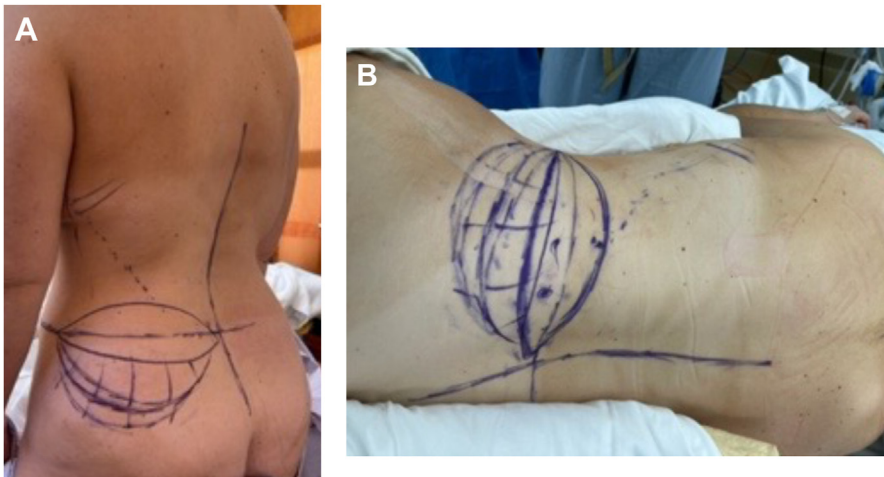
LAP flap markings shown preoperatively (A) and on the operating room table with the patient positioned in lateral decubitus (B). The skin paddle is marked as a solidly outlined ellipse transected horizontally by a line corresponding to the level of the umbilicus. The ellipse measures roughly 6 to 8 cm vertically and 25 cm along its anterior-to-posterior axis. Along the vertical axis, the ellipse is centered on the identified perforators (marked as dots in image B). The dominant perforator is typically found approximately 7 to 10 cm anterior to the posterior midline. Other more anterior perforators may be identifiable with doppler, but these generally smaller vessels are not suitable for microvascular transfer of the flap. That portion of the flap that includes gluteal fat elevated subcutaneously is identified here with hash marks caudal to the skin island.
